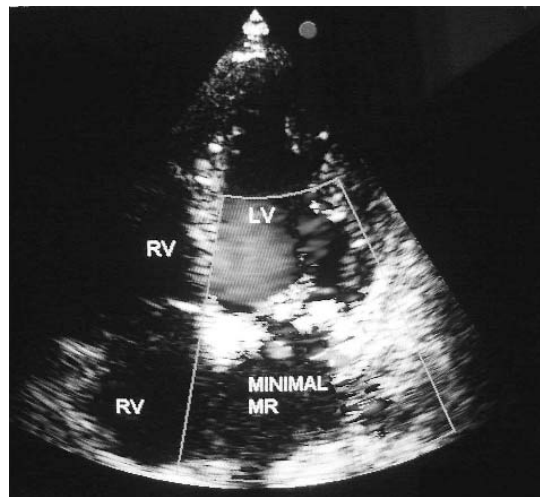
Postoperatively after 2 months an echocardiographic investigation revealed minimal mitral non-significant regurgitation
